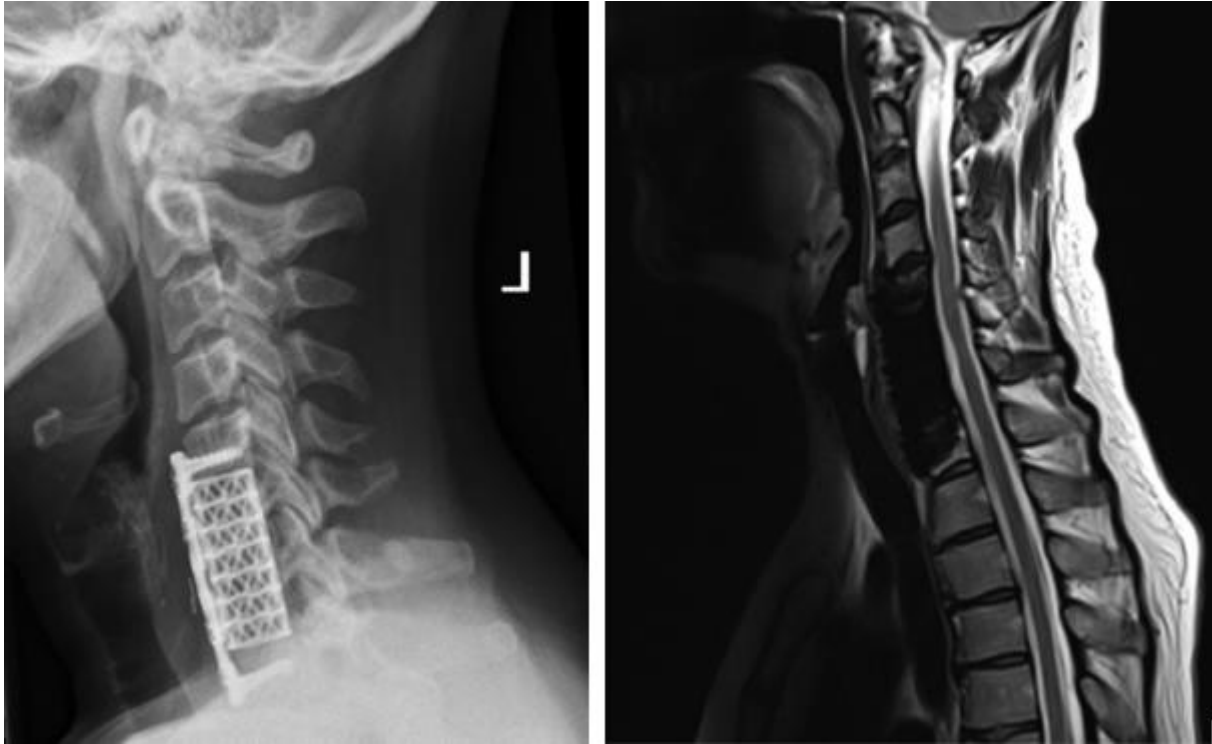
The post-operative X-Ray and MRI scans at 5 months follow-up.
